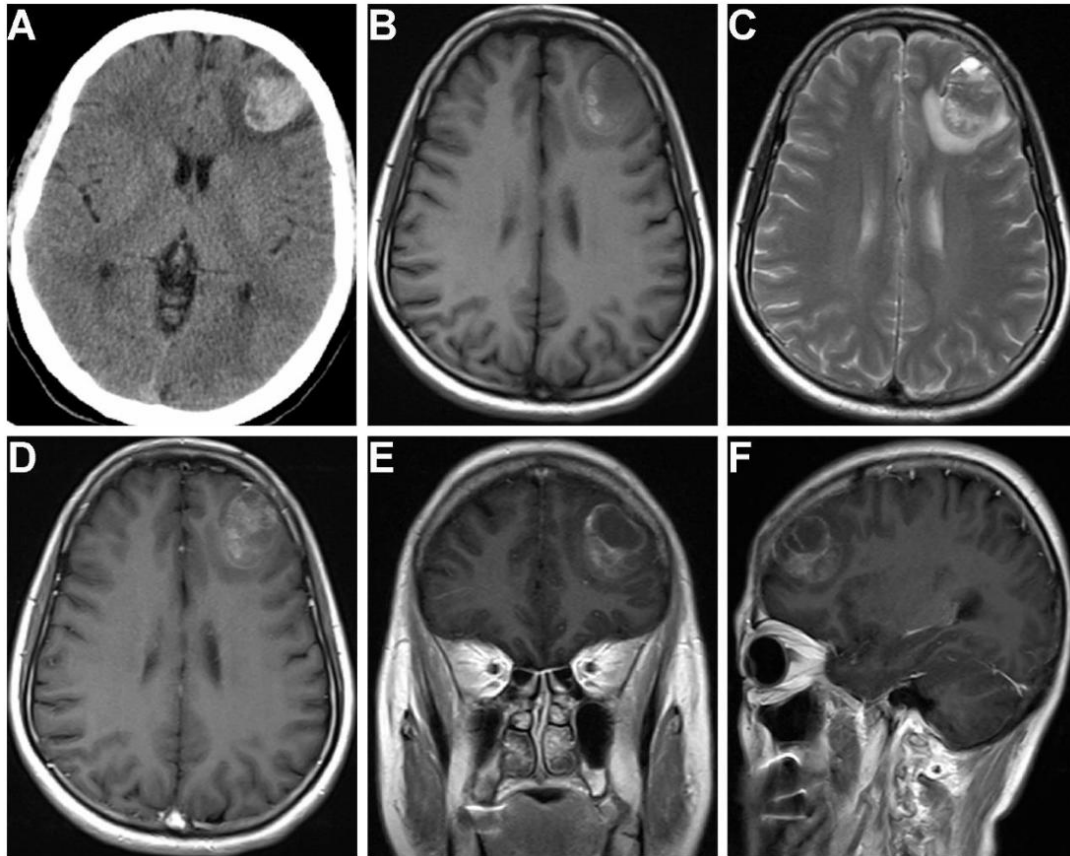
Head CT showed left frontal lobe high-density abnormal signal (A); MRI without contrast: T1 (B), T2 (C) weighted images showed left frontal mass high-low-mixed signals; Head MRI with contrast: coronal (E), sagittal (F) images suggested left frontal tumor with bleeding.
